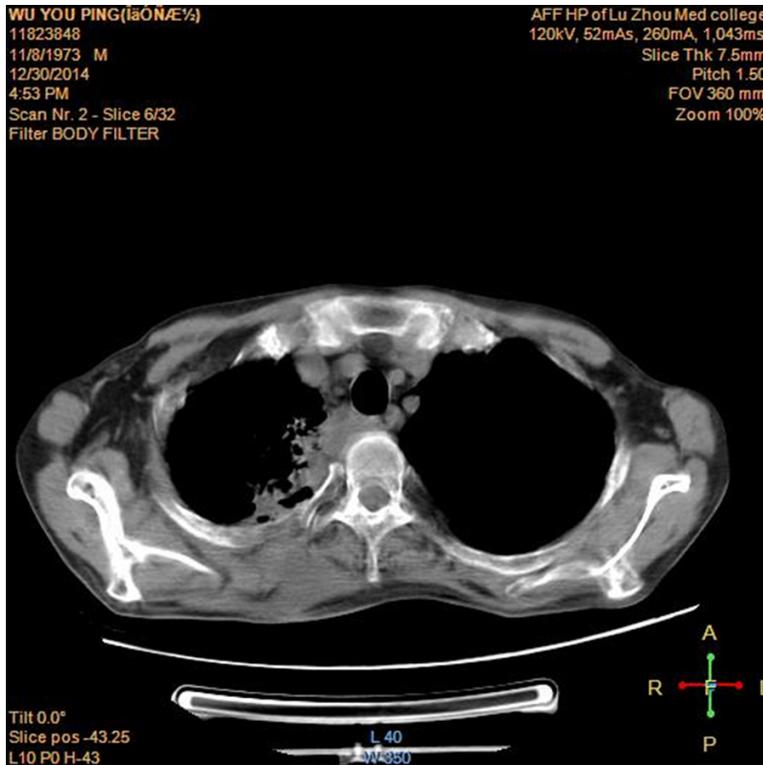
The chest CT showed the size of mass was decreased evidently.
